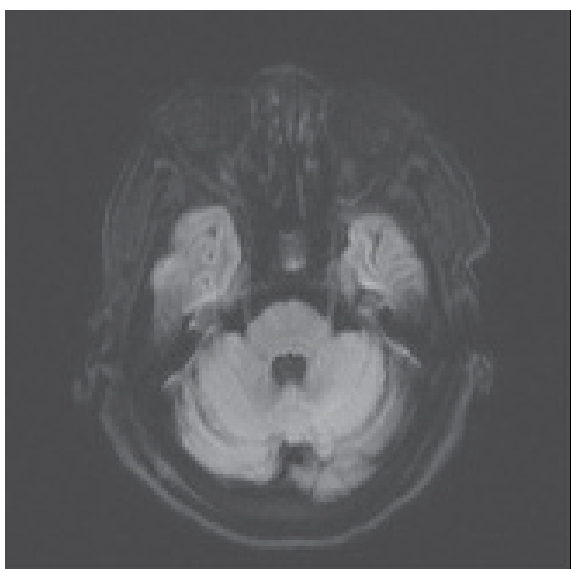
Post-operative brain MRI DWI showed resolution of prior enhanced lesion.
